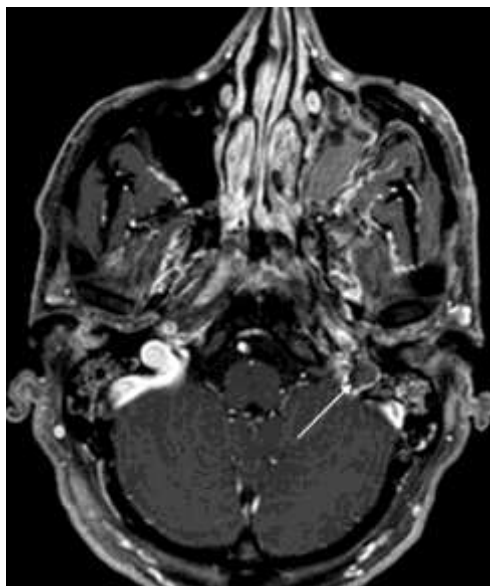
Post-traumatic dural venous sinus thrombosis; axial contrast enhanced T1-weighted turbo field echo sequence (same patient shown in Figure 35) further confirms the left jugular gulf thrombosis: normal enhancing vessel wall surrounding the nonenhancing thrombosed lumen (“delta sign”).
